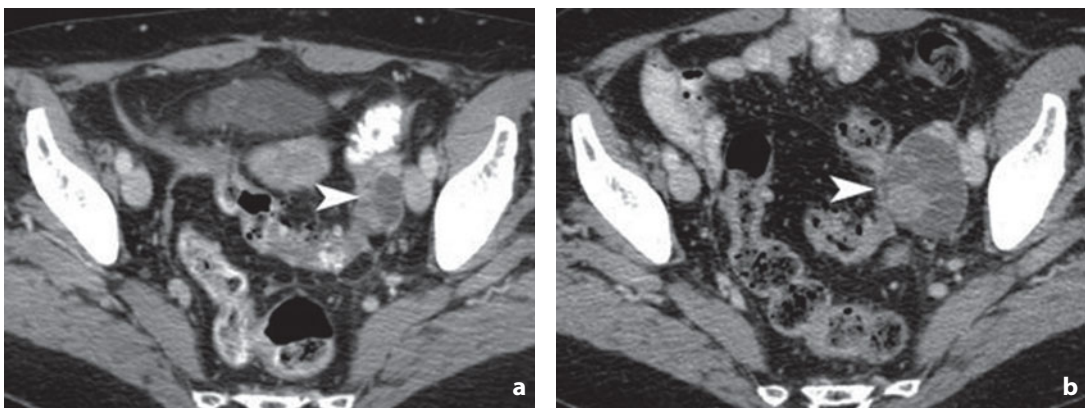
Computed tomography. Ovarian metastases from colon cancer. a Contrast-enhanced CT shows expansive left adnexal lesion with mixed structure (*arrowhead*). Subsequent contrast-enhanced CT follow-up (b) shows increased size of both the cystic and solid components
